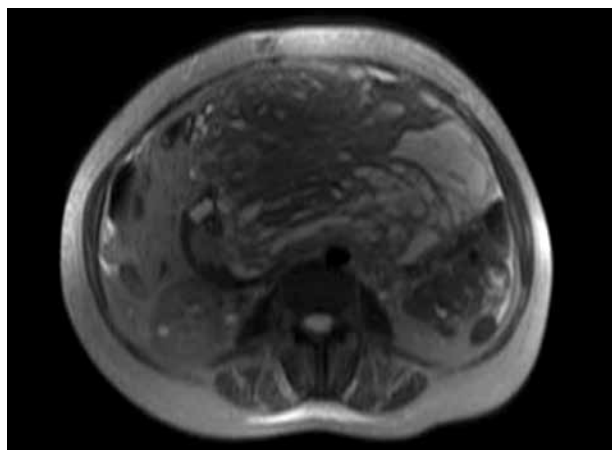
Cross-sectional magnetic resonance image of the patient
